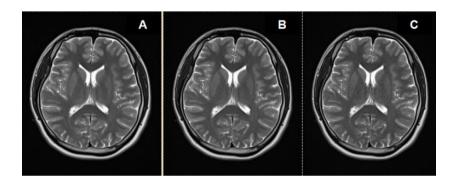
Brain MRI Image with GRAPPA R-factor of A = 1, B = 2, C = 3.
